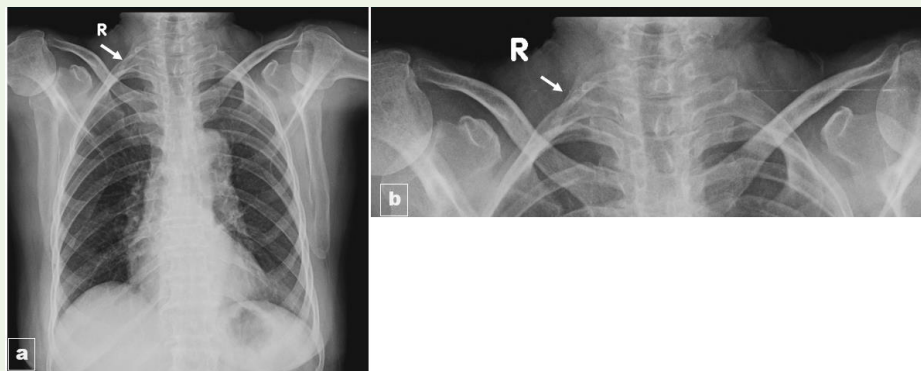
a) Full size Chest Radiograph, b) Magnified cropped image: Showing right sided cervical rib, which is seen extending till the medial third of clavicle. White arrow pointing at the right sided cervical rib.
